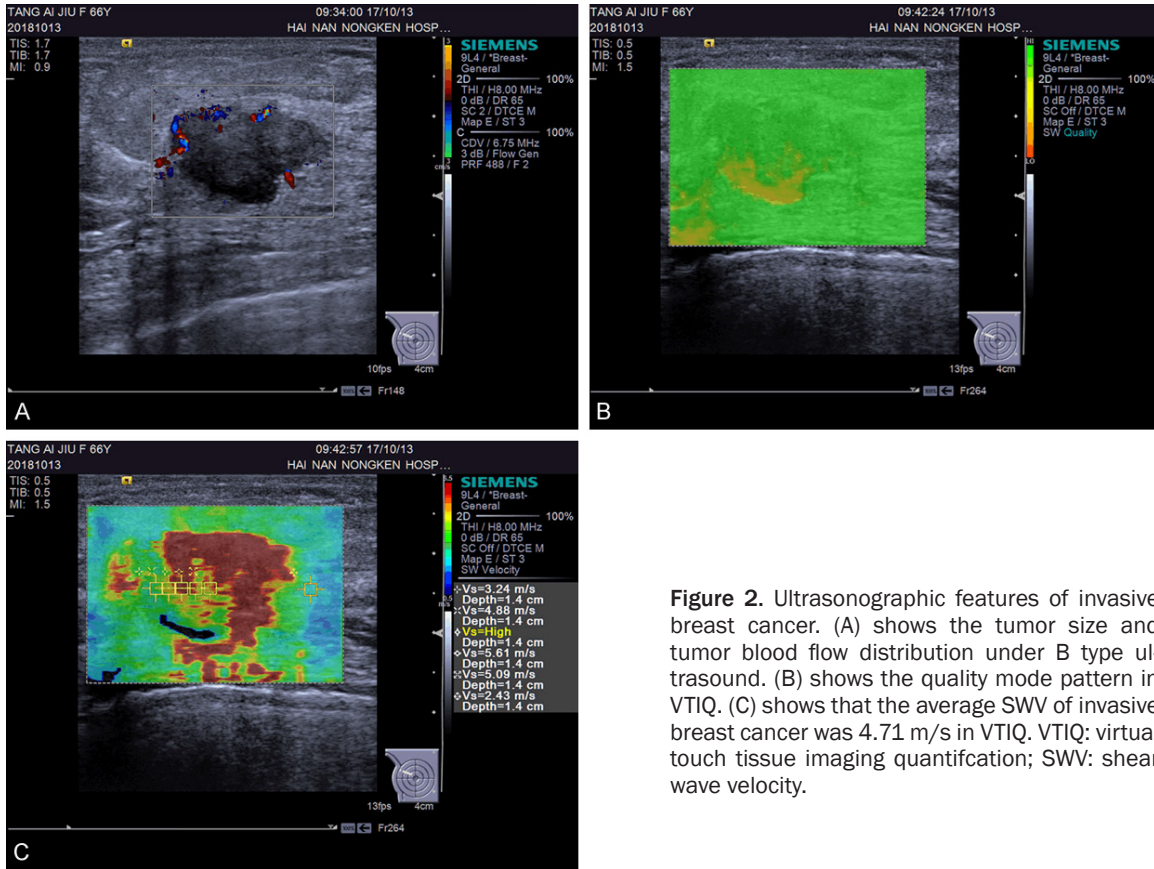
Ultrasonographic features of invasive breast cancer. (A) shows the tumor size and tumor blood flow distribution under B type ultrasound. (B) shows the quality mode pattern in VTIQ. (C) shows that the average SWV of invasive breast cancer was 4.71 m/s in VTIQ. VTIQ: virtual touch tissue imaging quantification; SWV: shear wave velocity.
